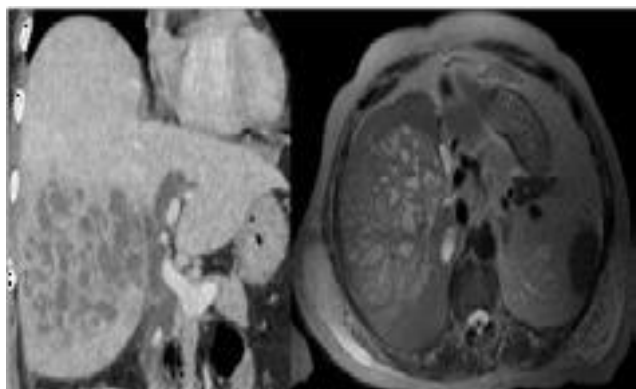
Coronal CT reconstruction (portal phase) and axial T2-HASTE MRI sequence. Complex multilocular liver abscess and cholelithiasis. Note the multiple septa as well as the numerous abscess micro and macro cavities.
